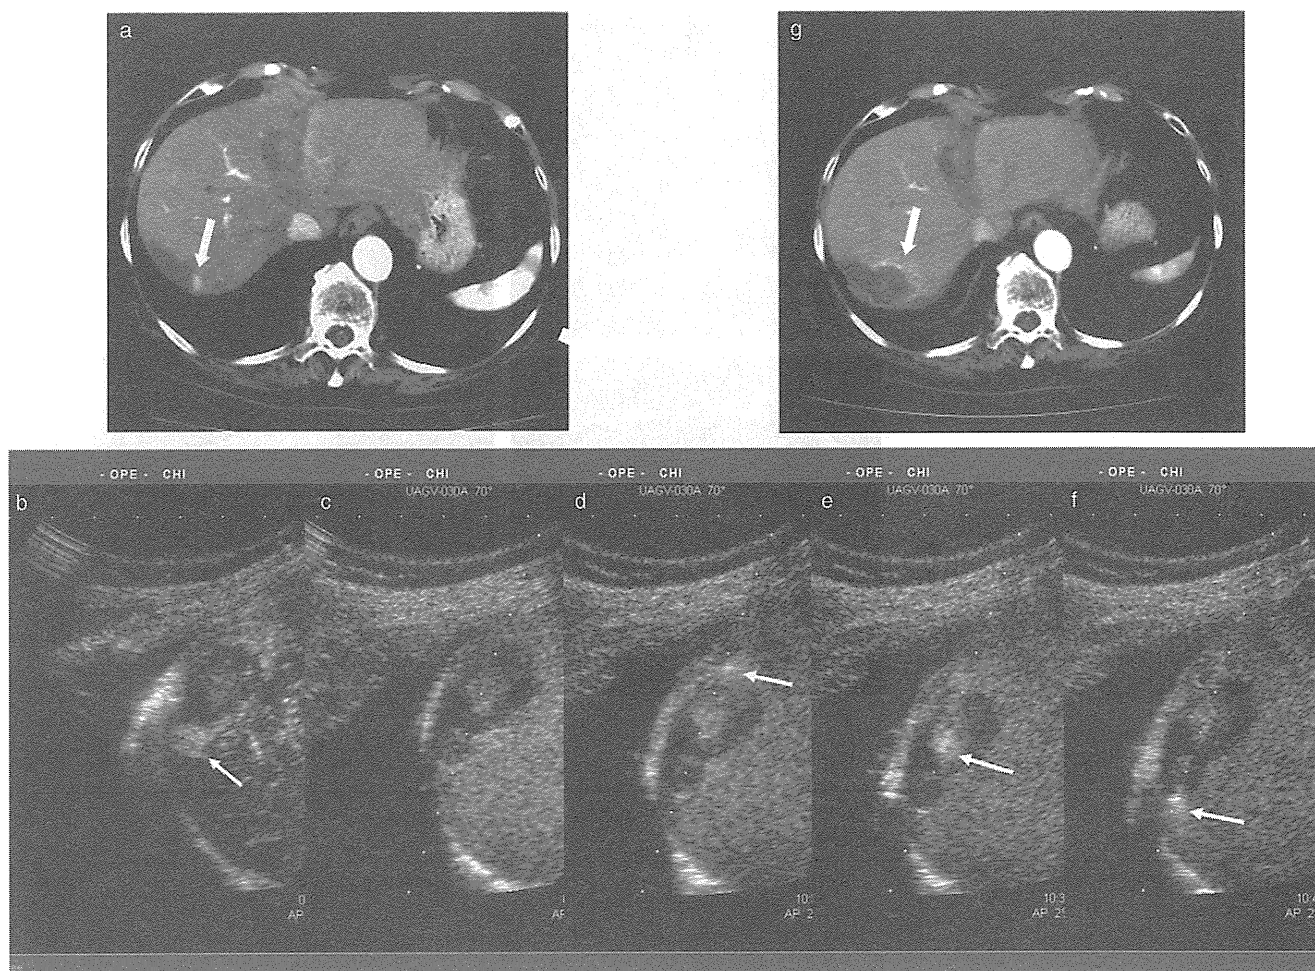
(a) An 80-year-old woman with hepatocellular carcinoma. Computed tomography (CT) revealed a nodule with hyperattenuation in the early arterial phase near a previously ablated lesion. (b) After injection of Sonazoid with artificial right pleural effusion, the nodule was clearly detected as a hyperechoic lesion (arrows). (c–f) Radiofrequency ablation of the nodule. (Arrows indicate the tip of radiofrequency needle). (g) Evaluation CT confirmed that the nodule was sufficiently ablated.
